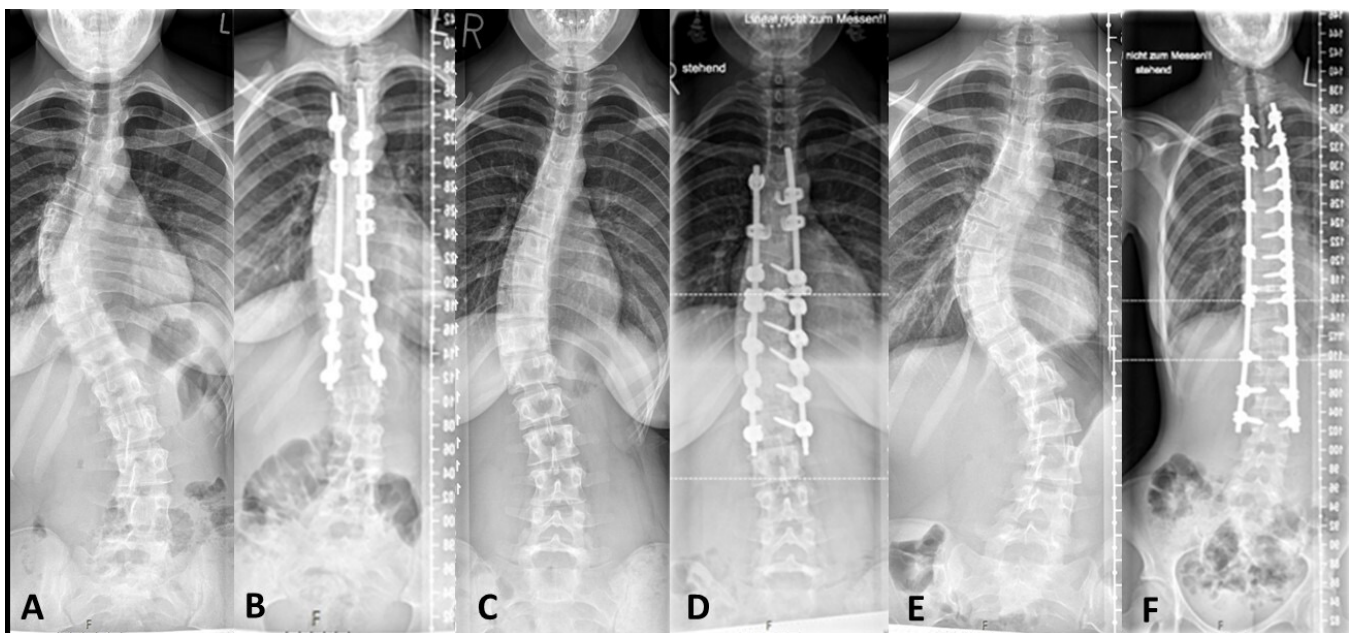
Example full-spine radiographs of a patient treated with hybrid-technique with screws, hooks, and tapes (A, presurgery and B, postsurgery); a patient treated with hybrid-technique with screws and hooks (C, presurgery and D, postsurgery); and a patient treated with all-screw technique (E, presurgery and F, postsurgery).
